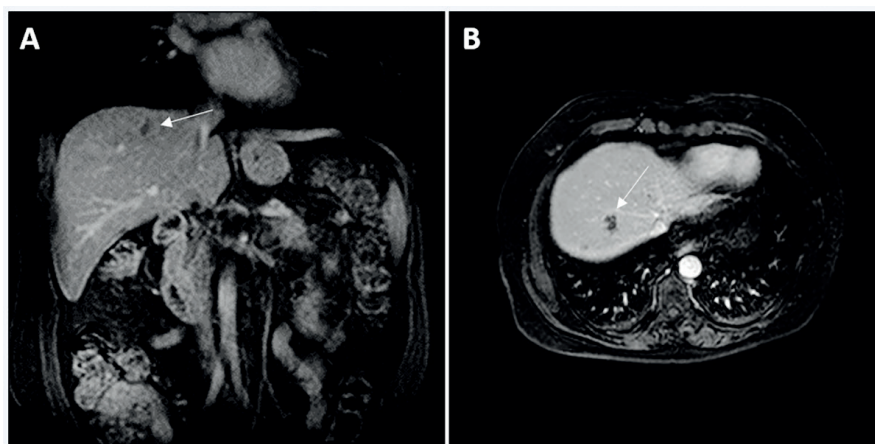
Nuclear magnetic resonance images of (A) the main coronal contrast and (B) the axial contrast. The arrows point to the lesions formed by the presence of the adult *Fasciola hepatica* parasite.
